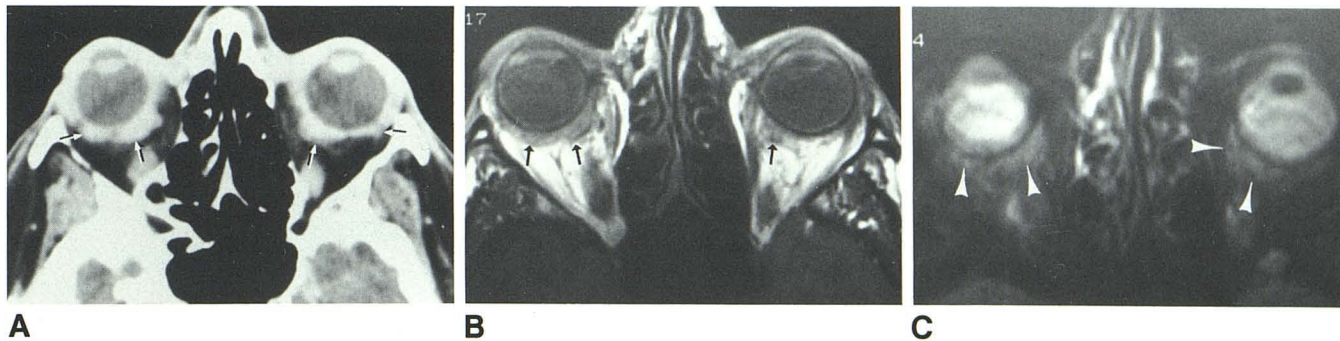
Orbital pseudotumor with uveal-scleral thickening. A, Axial CT shows bilateral, enhancing uveal-scleral thickening (arrows). B, Axial surface-coil MR, T1-weighted image (TR = 600 msec, TE = 25 msec). MR clearly defines bilateral uveal-scleral thickening (arrows), which
